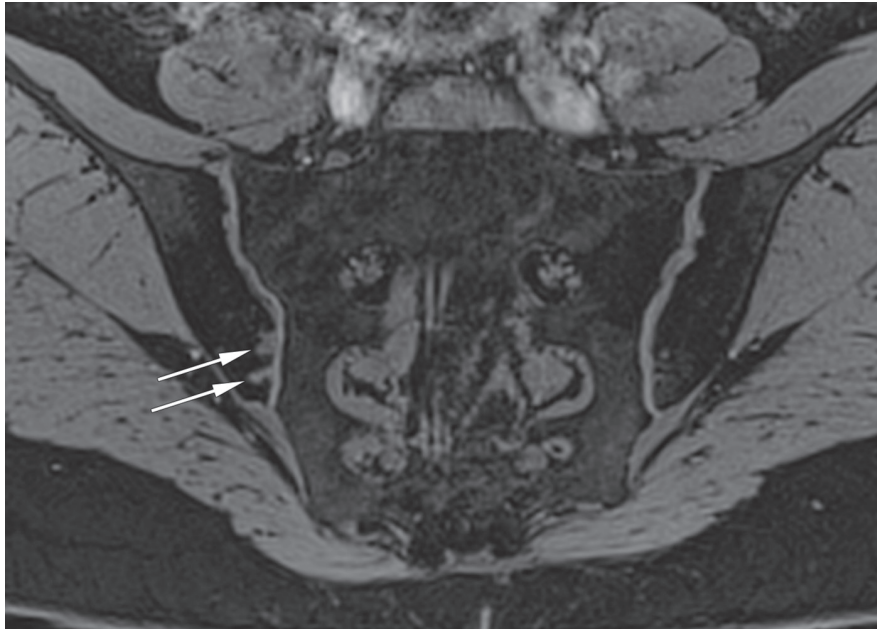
Patient with early axial spondyloarthritis. The VIBE sequence shows a high signal intensity of the articular cartilage and depicts osseous erosions in high detail (arrows) due to the saturated fat signal. These erosions would have escaped detection in conventional T1-weighted images.
